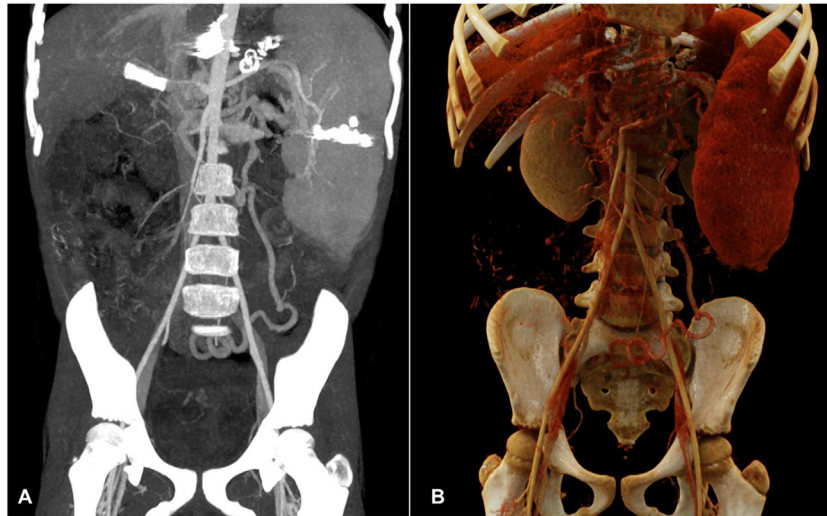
Computed tomography (CT) images of the abdomen with coronal reconstruction in maximum pixel projection (A) and rendering volume (B) showing the dilated and tortuous inferior mesenteric vein.
